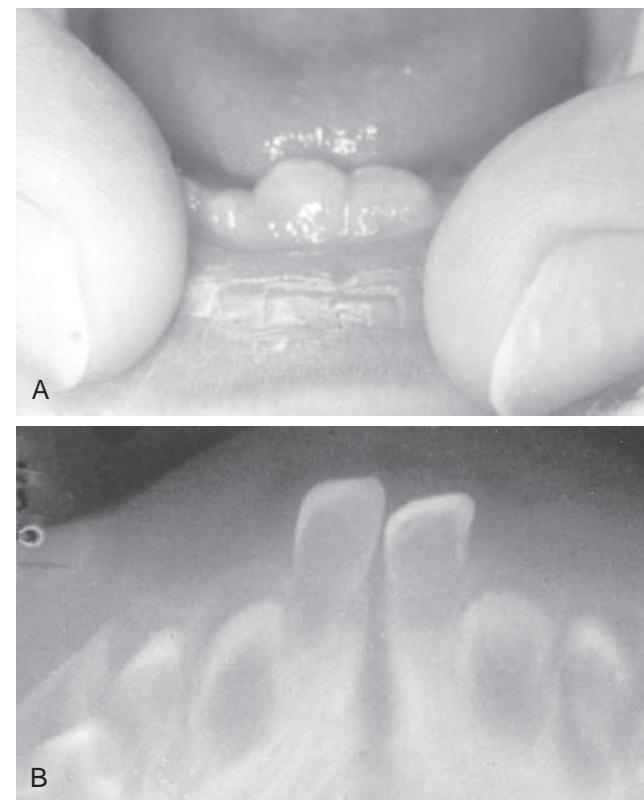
(A) Parents of a 3-week-old infant were concerned about the elevated mass of tissue on the mandibular ridge. (B) Radiograph revealed two primary central incisors that would soon erupt. The ungloved fingers in the photograph are those of the infant's parent.
